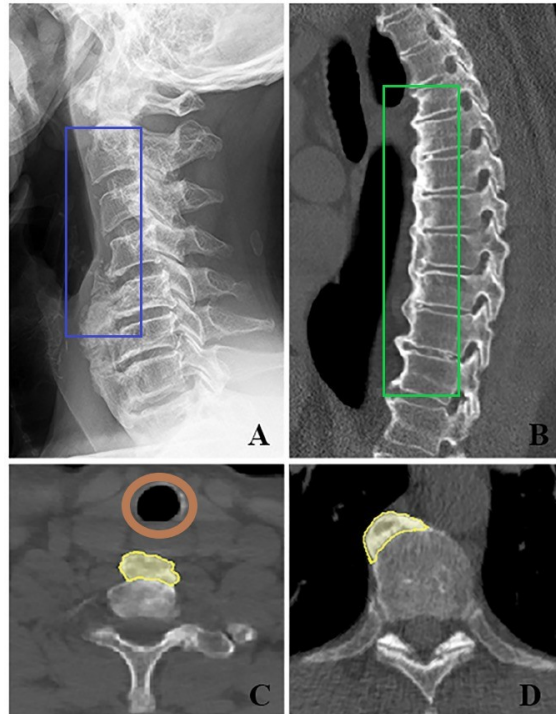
Patterns of DISH in cervical and thoracic spine. (A) Ossifications' Bar-like pattern (blue rectangle) in a sagittal radiograph of cervical spine. (B) Ossifications' "flowing wax" pattern (green rectangle) in a sagittal CT of thoracic spine. (C) Axial CT of cervical vertebra showing, in yellow and brown, the ossifications and the trachea, respectively. (D) Axial CT of a thoracic vertebra showing, in yellow, the ossifications [Adapted from[8]].
